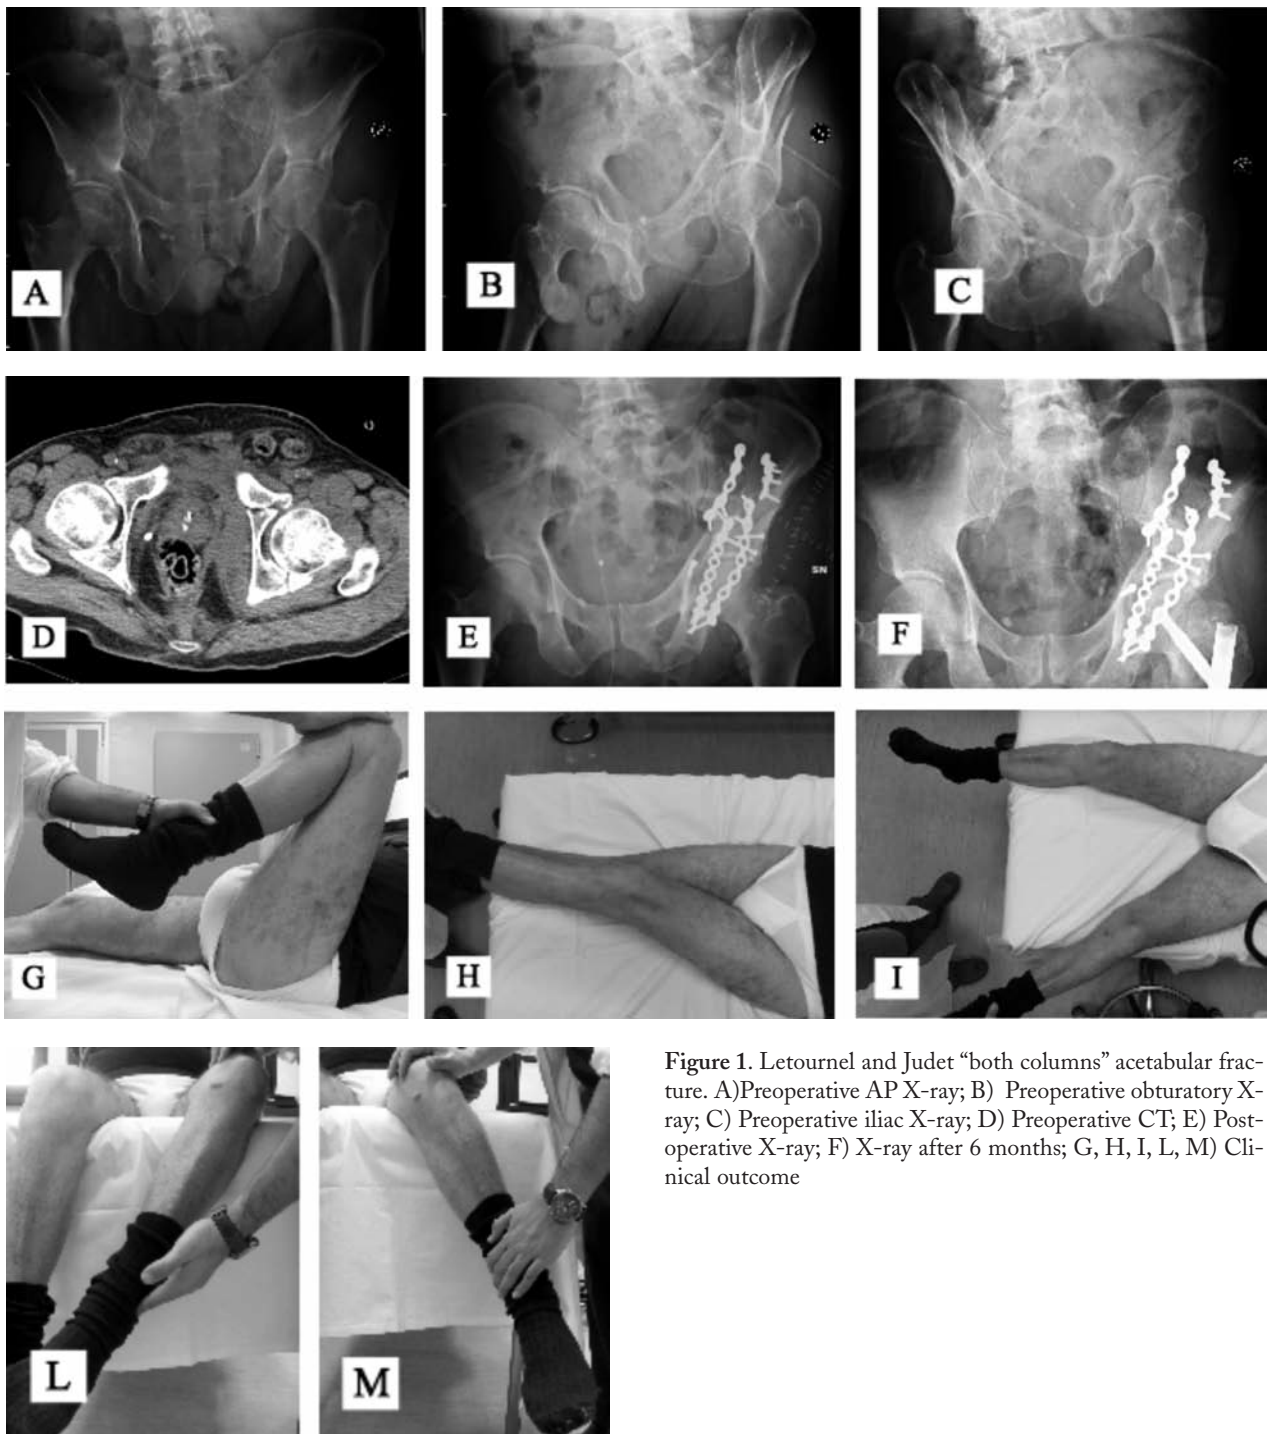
Letournel and Judet “both columns” acetabular fracture. A) Preoperative AP X-ray; B) Preoperative obturator X-ray; C) Preoperative iliac X-ray; D) Preoperative CT; E) Post-operative X-ray; F) X-ray after 6 months; G, H, I, L, M) Clinical outcome
